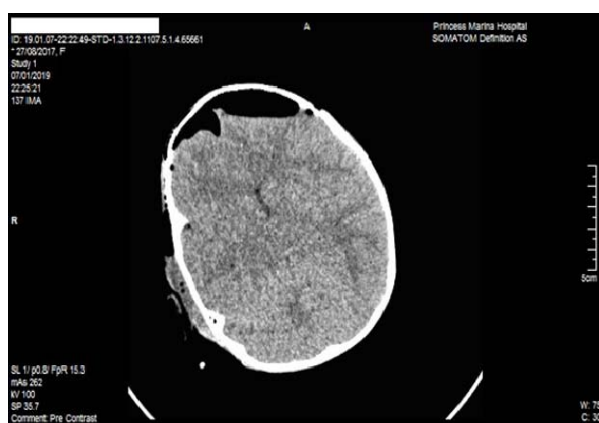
The second CT head demonstrating “Mount Fuji sign” (see arrow).
